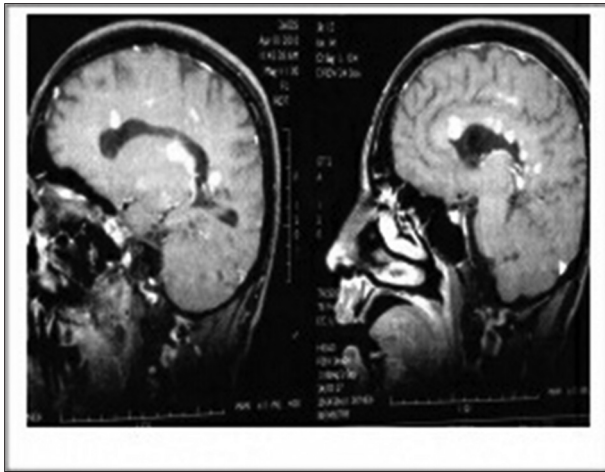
Magnetic resonance imaging brain of multiple sclerosis patient showing enhancing pericallosal plaques (Dawson fingers)
